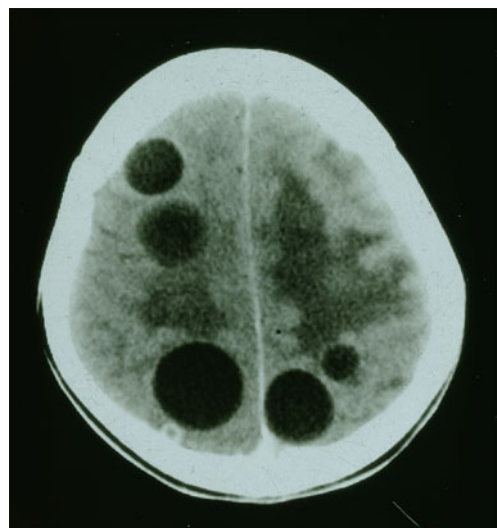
Pre-operative CT scan of a 6-year-old Kazakh boy with increased intracranial pressure and hemiparesis which showed five intracranial cystic masses on frontal and parietal regions, manifested as thin-walled, well-demarcated, and round cystic lesions subsequently diagnosed as hydatid cysts intraoperatively
